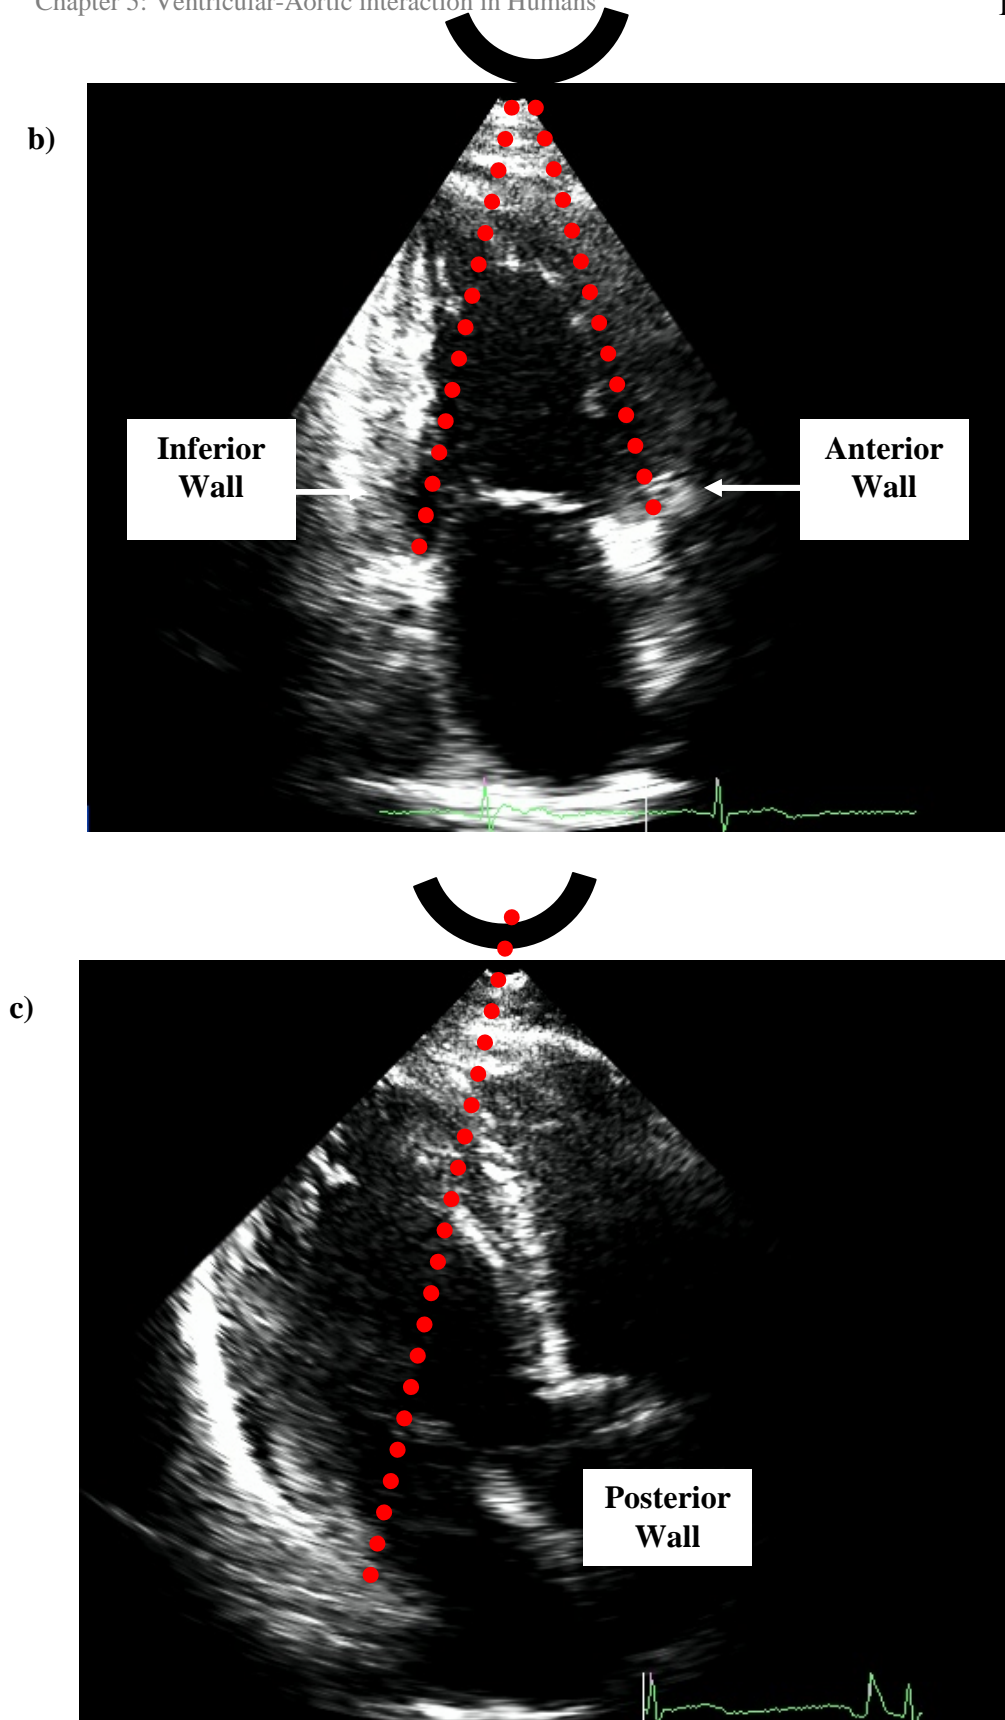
An example of an a) apical four-chamber view, b) apical two-chamber view and c) apical three-chamber view of the heart. The lines represents where the sample volume is placed to measure septal, lateral, anterior, inferior mitral annular wall velocities respectively.
